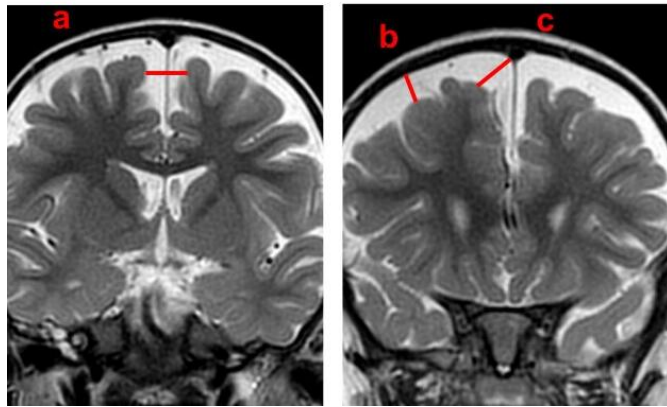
The figure shows the measurement of the extraventricular cerebrospinal fluid compartments in a Magnetic Resonance image of a 33-months-old girl affected by benign external hydrocephalus. The following measurements are shown: (a) interhemispheric fissure (12 mm), (b) craniocortical width (8.4 mm), and (c) sinocortical width (12.4 mm).
